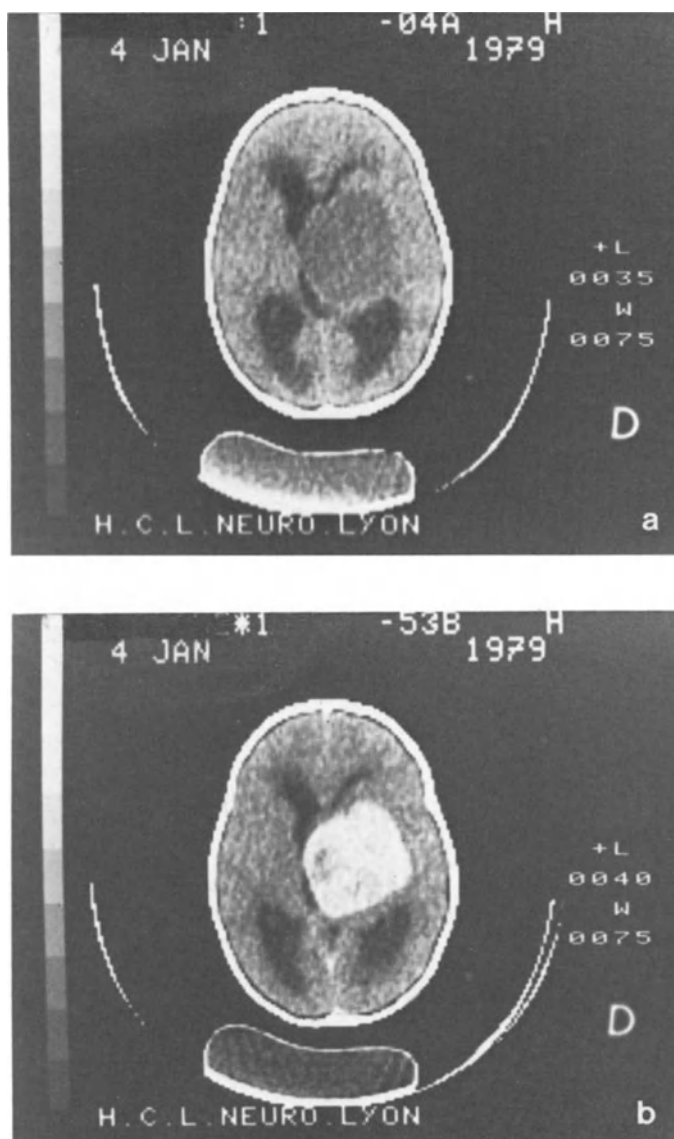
Spongioblastic astrocytoma. a) Pre-contrast CT: hypodense mass. b) Post-contrast CT: massive enhancement
